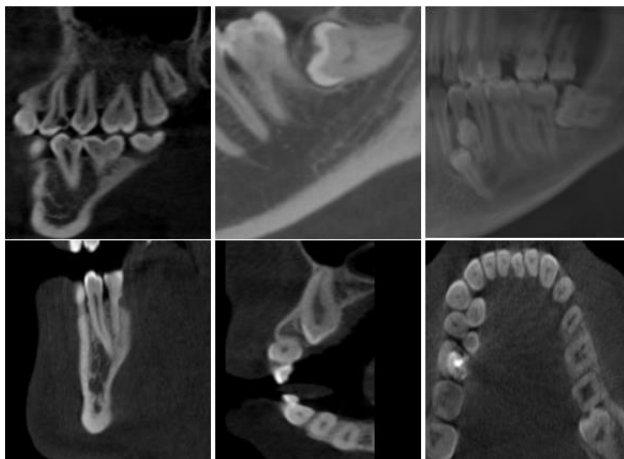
Examples of different dental anomalies by CBCT views.
